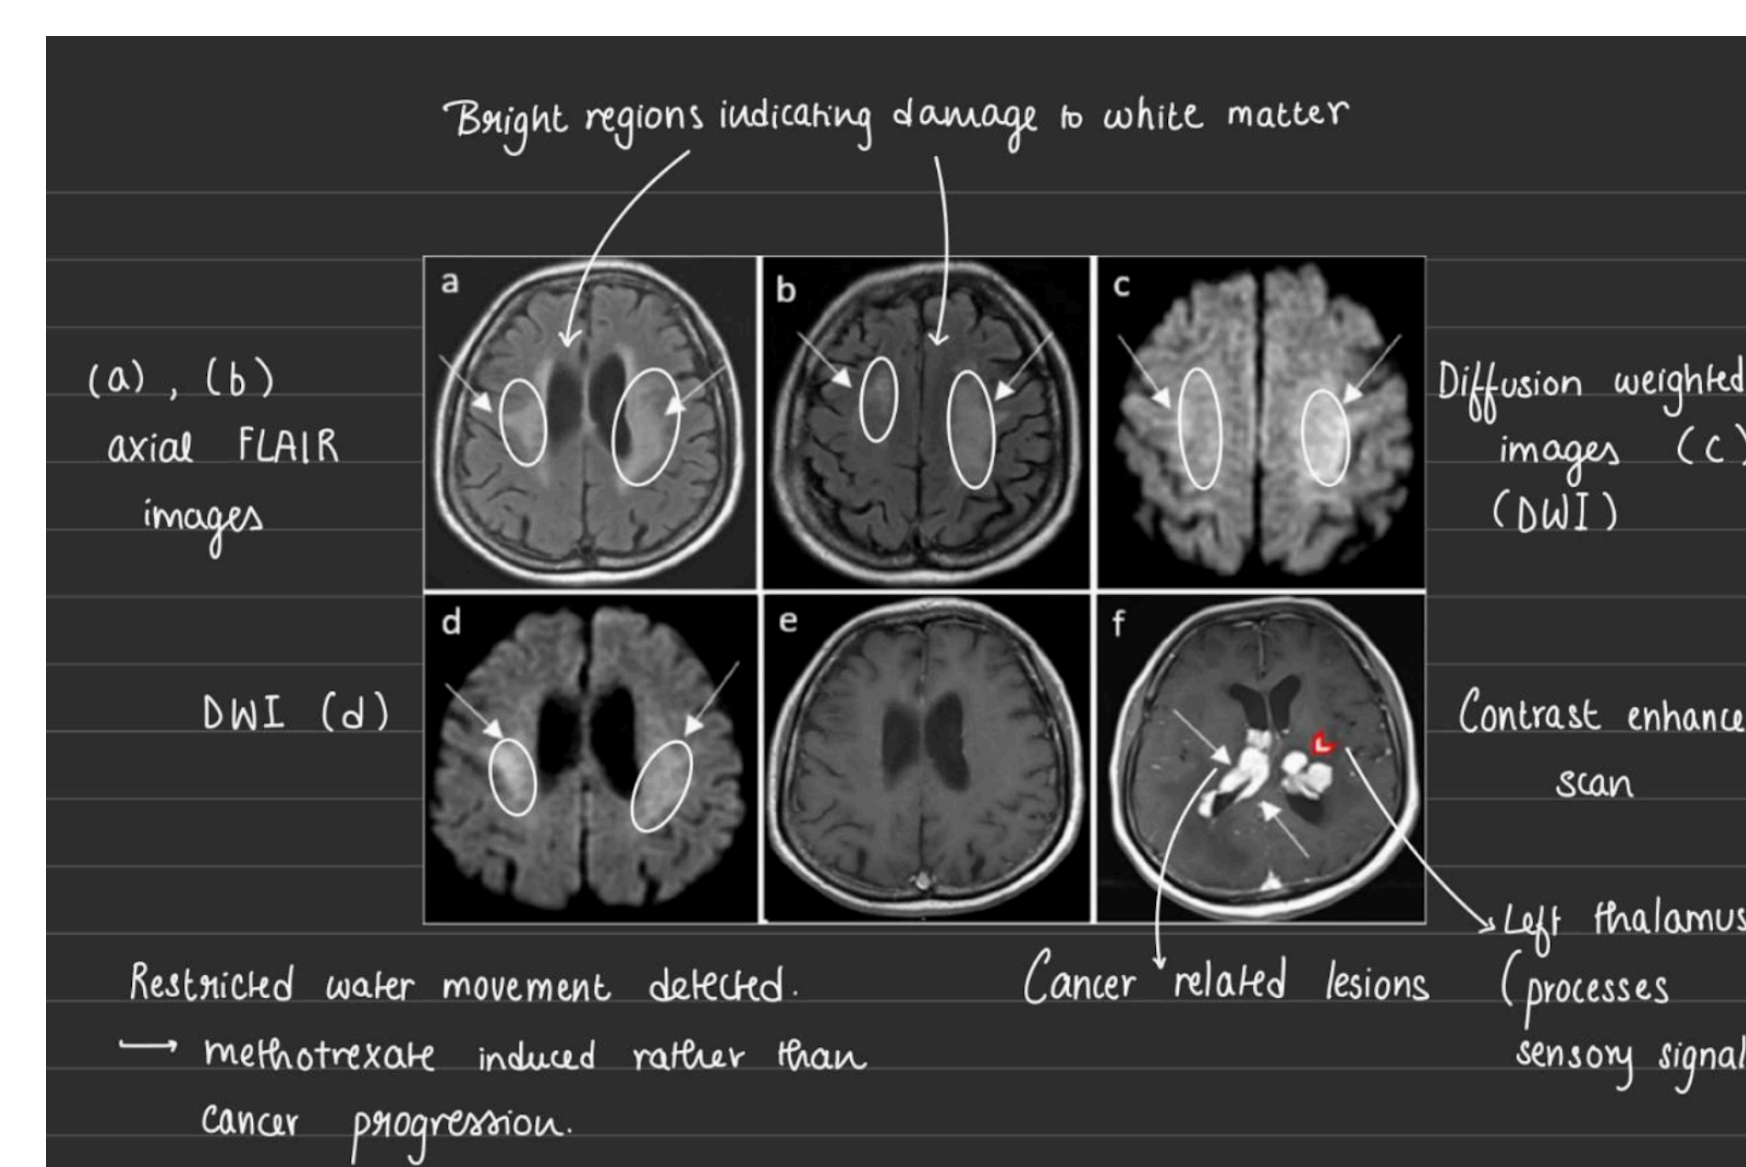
Methotrexate: White matter damage, DWI confirms toxicity, thalamus lesions
